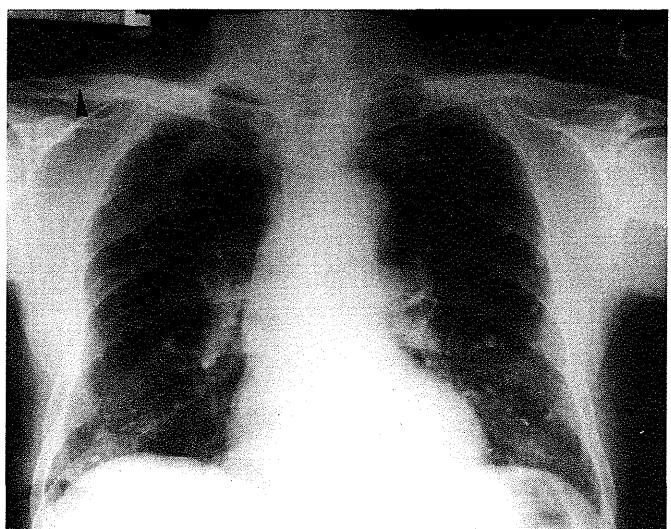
Chest X-ray showing bilateral multiple fibrocalcified foci, background nodularities and fibrotic change over right apex. Note lytic lesion (arrowhead) with well-defined border over right clavicle.
